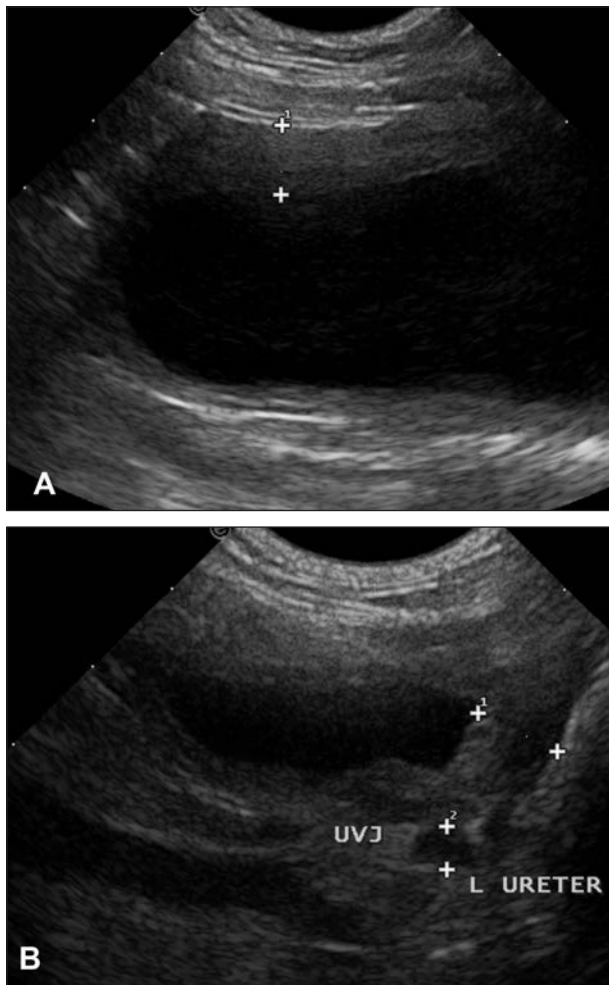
Same ultrasonographic images as in Figure 1. A—The cranioventral aspect of the urinary bladder wall is thickened (7.3 mm between cursors) on the longitudinal image. B—On the transverse image of the urinary bladder, notice that there is trigonal thickening (7.9 mm between first set of cursors) and a dilated left (L) ureter (3.9 mm between second set of cursors) at the ureterovesical junction (UVJ).
